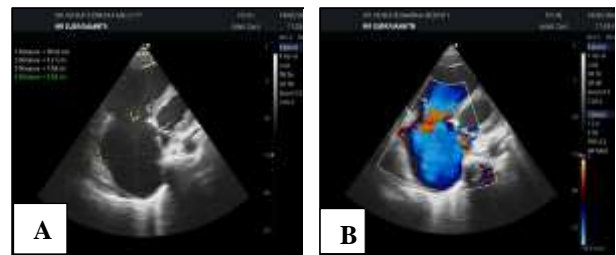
(A and B): Echocardiogram reveals dilated RS and RV with TR.
